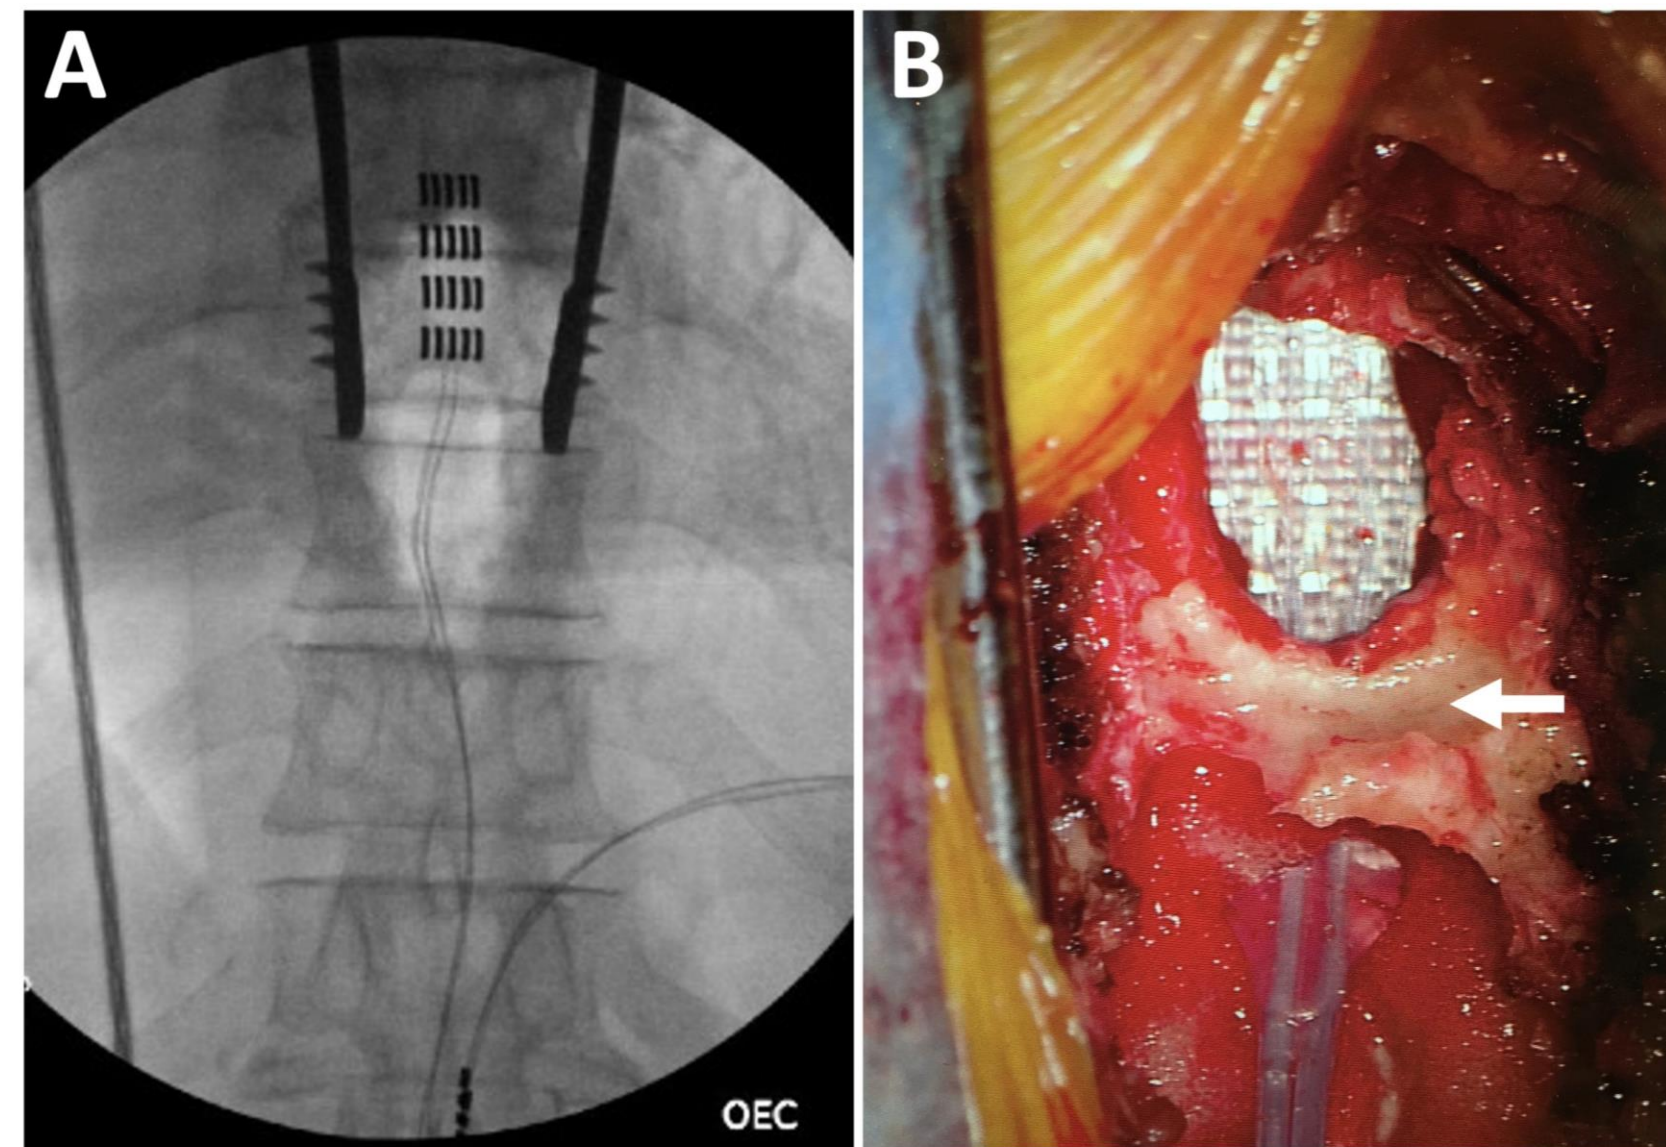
Case example of “Paddle-Under-Bridge” technique. A. Intraoperative X-ray, AP view, showing SCS paddle lead centered over T8/9 - disc interspace. Note the hypodensity from T8 to T10 indicating the extent of the surgical field. B. Intraoperative photograph depicting paddle lead positioned under the residual T9 bone “bridge” (arrow). Note the two-level ligamentum flavum removal at and below the level of SCS paddle lead placement.
